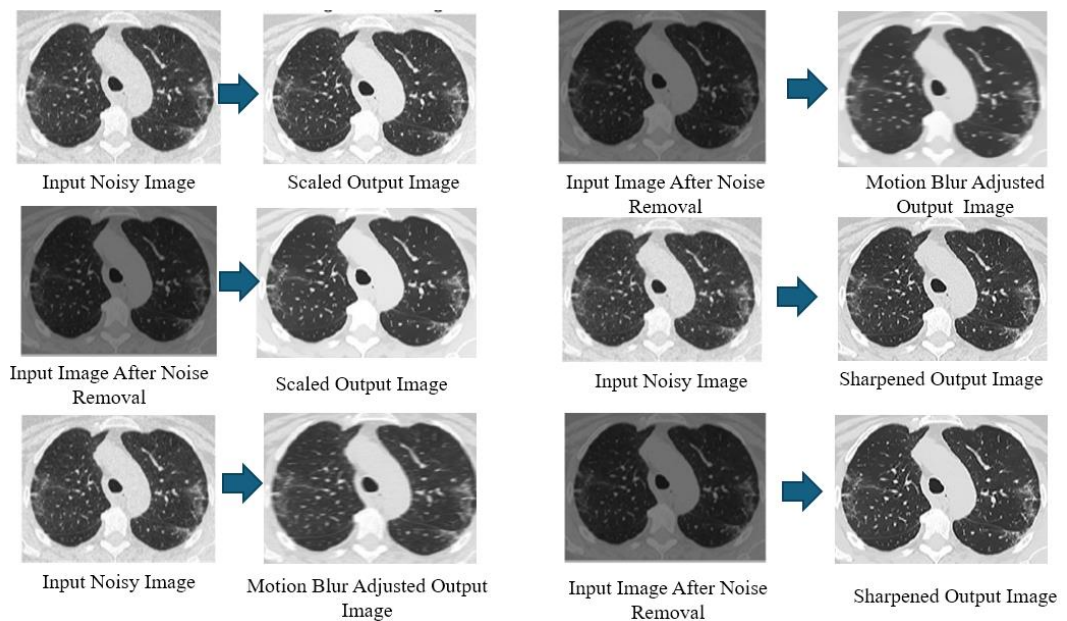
BM3D Denoising Impact with Various Augmentation Techniques on CT Images.
